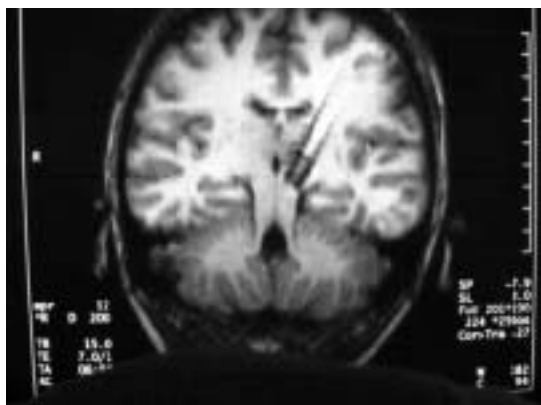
This figure is a MRI scan performed after implantation. It shows the two DBS electrodes placed in the left PVG and the left VPL, respectively in a patient with chronic post-stroke pain.
